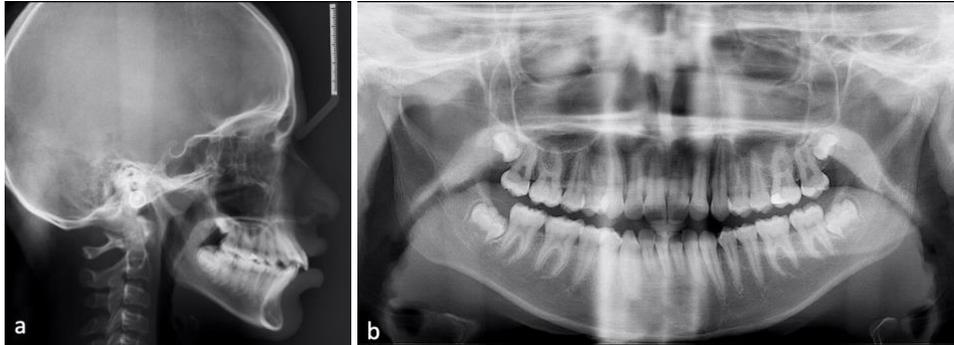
a-b : Pre-treatment lateral cephalogram and panoramic radiograph.
